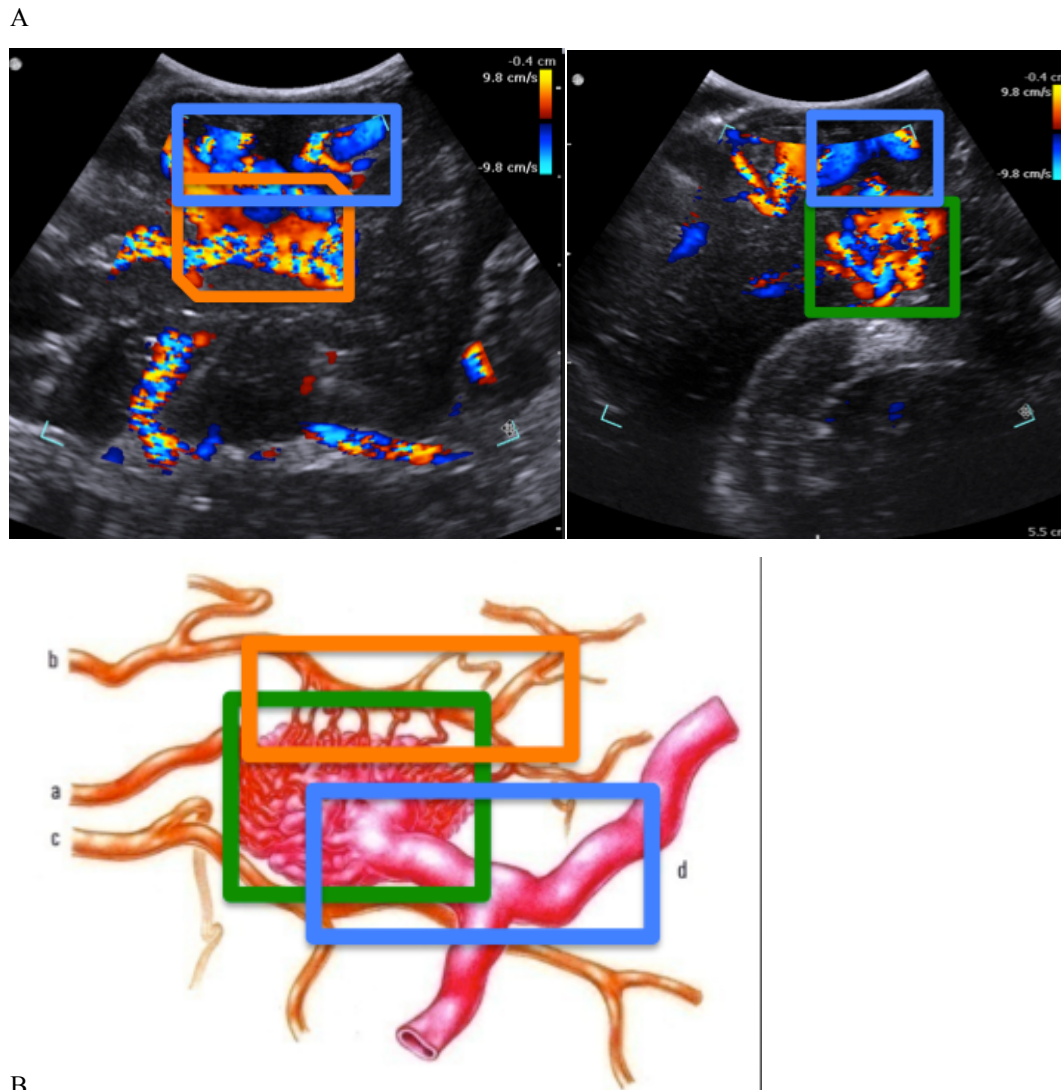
A-B Colordoppler ultrasound acquisition: visualization of the AVM and relationships with the surrounding parenchyma. In green the nidus, in red the arterial afferents and in blue the venous drainage.
